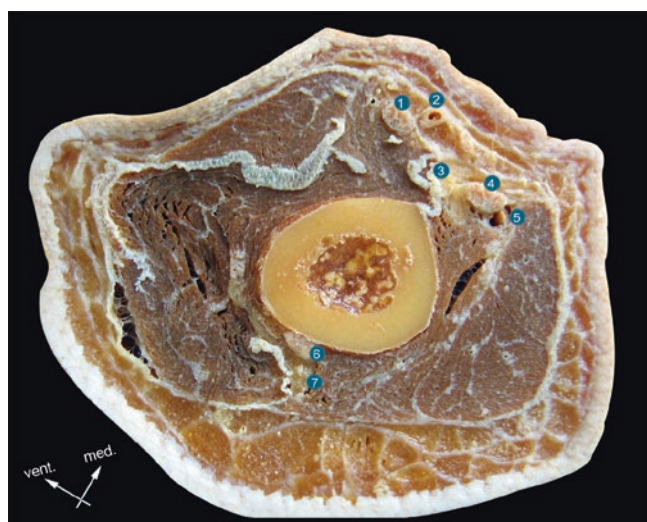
Section in 1/4 distal portion of the arm with materialisation of ultrasound beam for performance of a truncal block of the radial nerve
